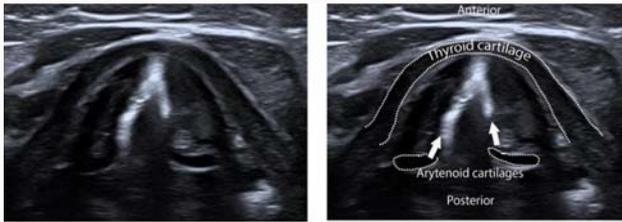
Ultrasound images of larynx and vocal folds (white arrows).
